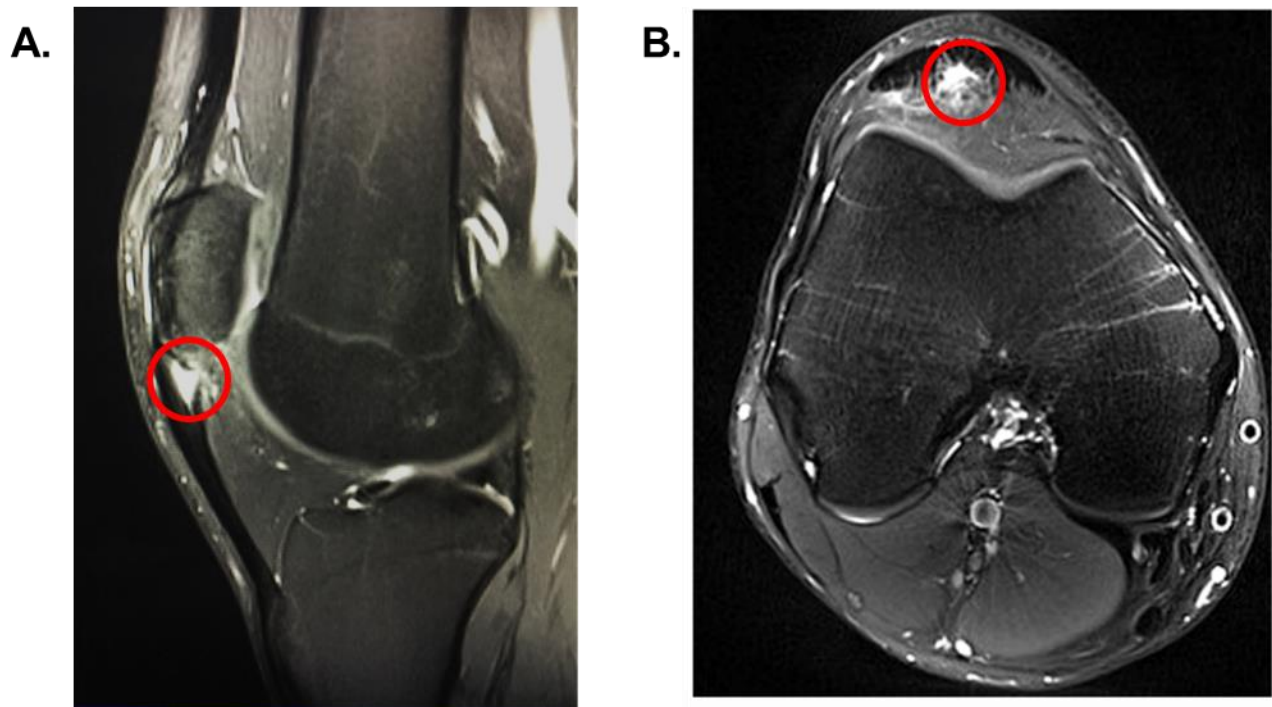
MRI of Patellar Tendinopathy in Saggital (A) and Transverse (B) planes (Baar 2019). Notice the MRI reactivity (outlined in red) just distal to the patella indicating disrupted collagen structure.
